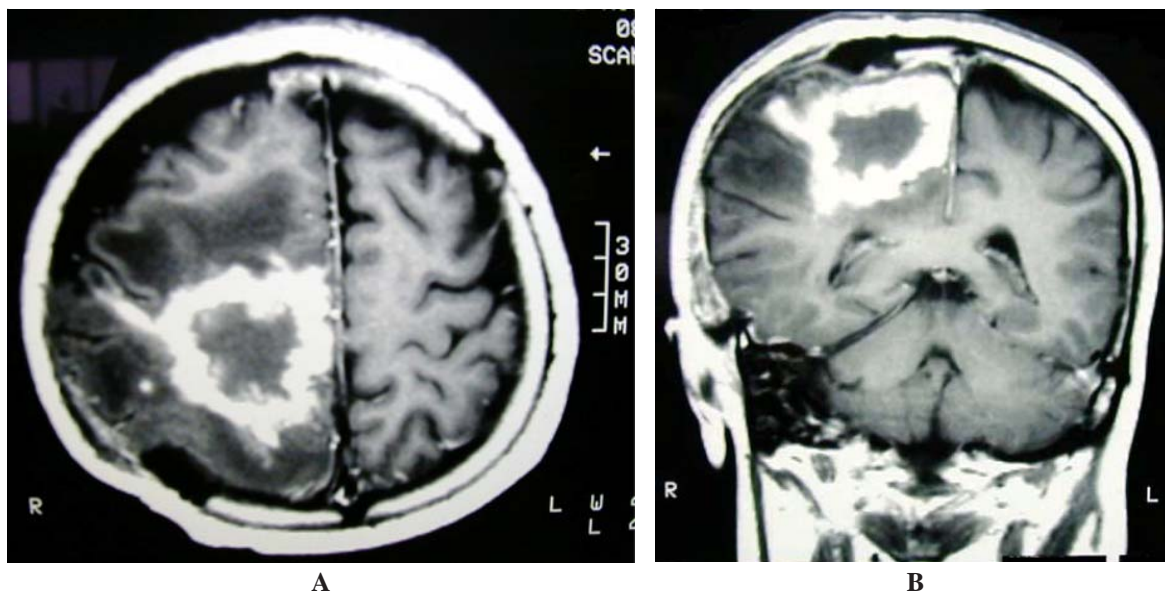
Axial view (A) and coronal view (B) of the magnetic resonance imaging of the brain showed an irregular ring enhancing hypointensity lesion in T1-weighted image with Gadolinium, 5 cm in diameter, with surrounding vasogenic edema at right frontoparietal area and gyral enhancement of the adjacent meninges
